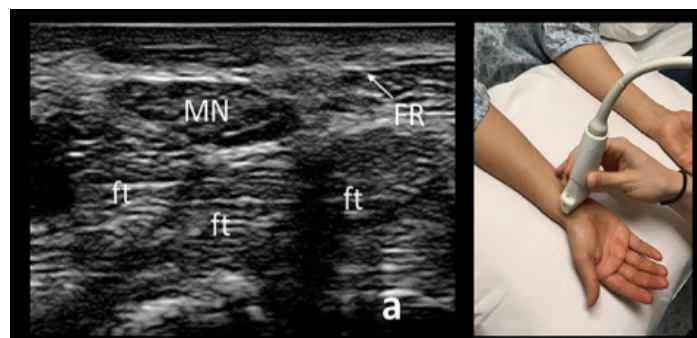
Hand position during median nerve sonography
